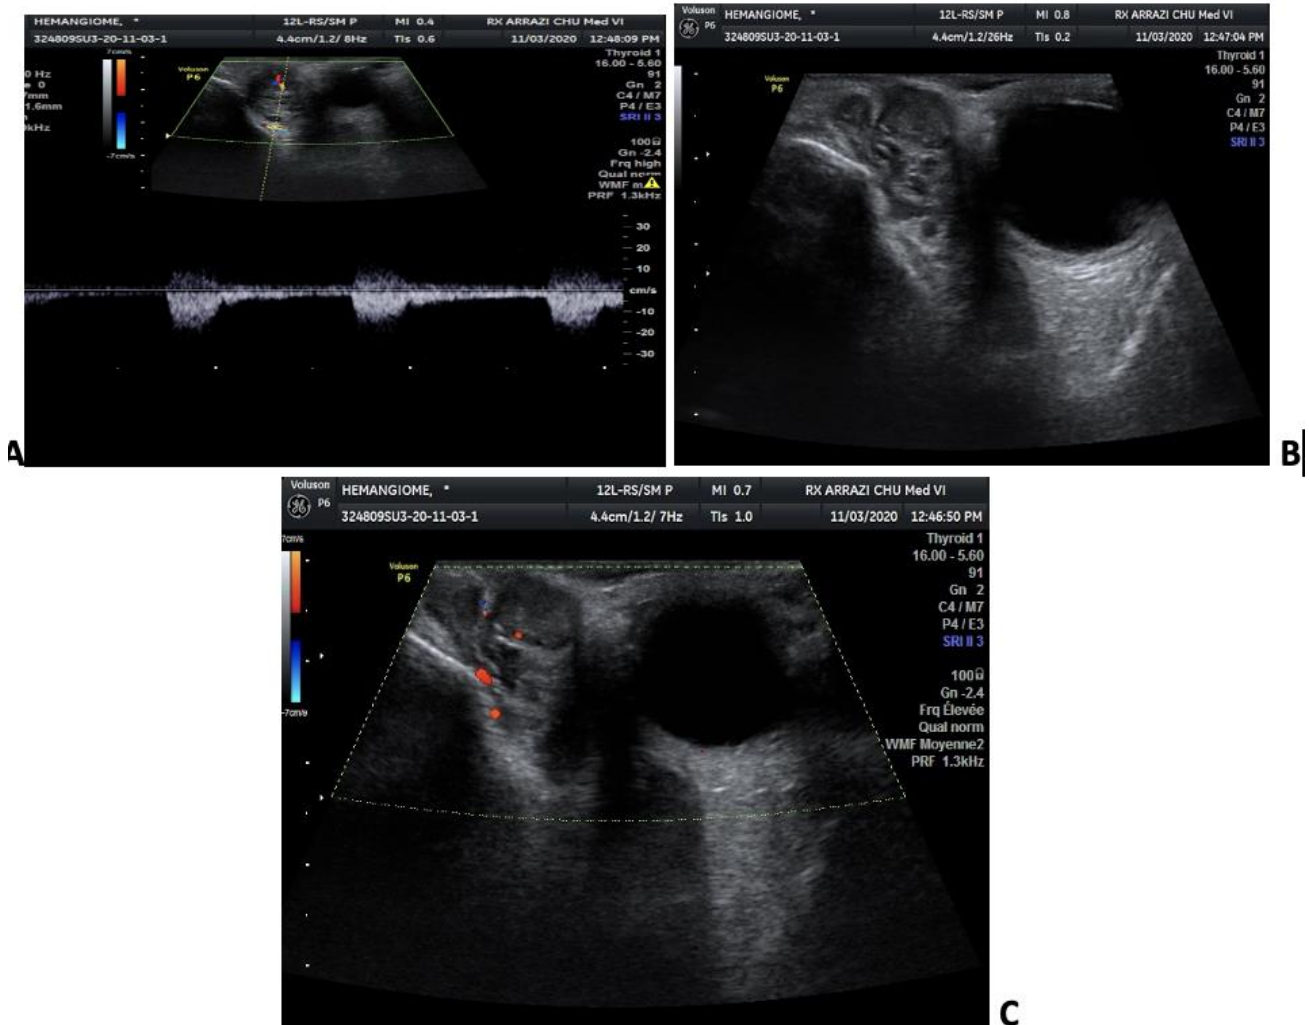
(A,B,C): Orbital lesion formation intra- and extra-conical, well-defined, hypoechoic, heterogeneous, vascularized on color Doppler with low resistance arterial flow
